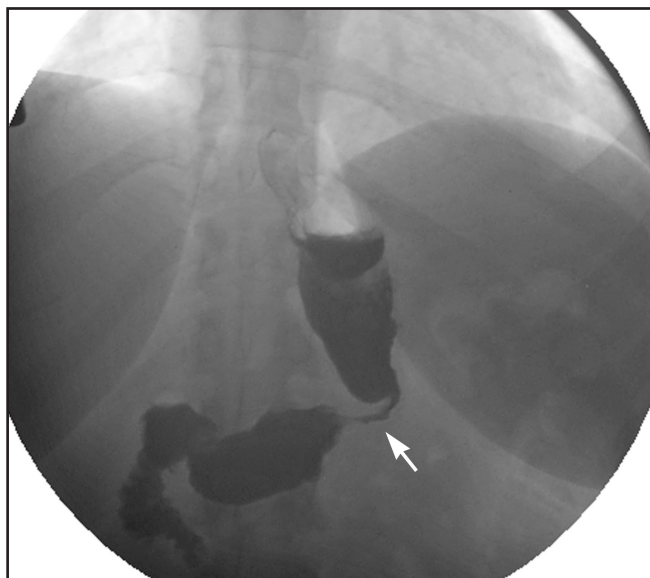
The “O sign.” (A) Scout film. The herniated stomach has tilted the band along its horizontal axis and the band has O configuration (black arrow) on supine abdominal radiograph. (B) Upper GI series. The herniated stomach (white arrow) with stomal obstruction projects anterior to the band with (black arrow).
